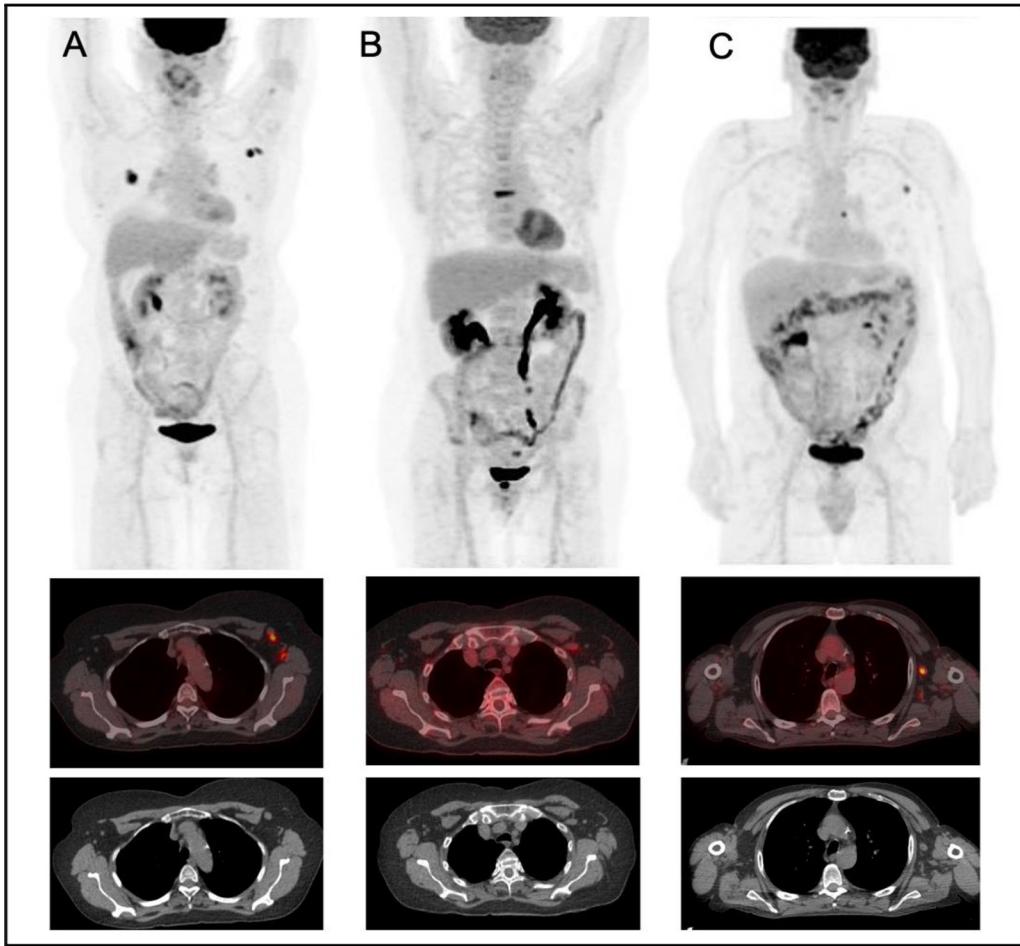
Whole-body maximum intensity projection images and transaxial images of fused PET/CT and CT show: A) Multiple hypermetabolic axillary lymph nodes are identified, in this 66-year-old female patient with a primary adenocarcinoma of the right middle lobe, 9 days after the first dose of Moderna vaccine. The most intense lymph node demonstrates a  $SUV_{max}$  of 13.1, and measures 9 mm in the short axis. These lymph nodes are ipsilateral to the vaccine injection and contralateral to the known primary malignancy and thought to be vaccine-related rather than metastatic disease. B) In comparison, this 69-year-old female patient with minimally FDG-avid left perihilar adenocarcinoma, 7 days after the first dose of Moderna vaccine, demonstrates a more typical PET/CT appearance. The most intense axillary lymph node is barely perceptible on the MIP image, measuring 7 mm in the short axis with a  $SUV_{max}$  of 2.7. Incidental benign compression fracture in the midthoracic spine is also noted. C) In this 59- year-old male with primary adenocarcinoma in the left perihilar region, moderate hypermetabolic activity ( $SUV_{max}$  6.6) is noted in a 9 mm left axillary lymph node 10 days after the first dose of Pfizer-BioNTech vaccine.
